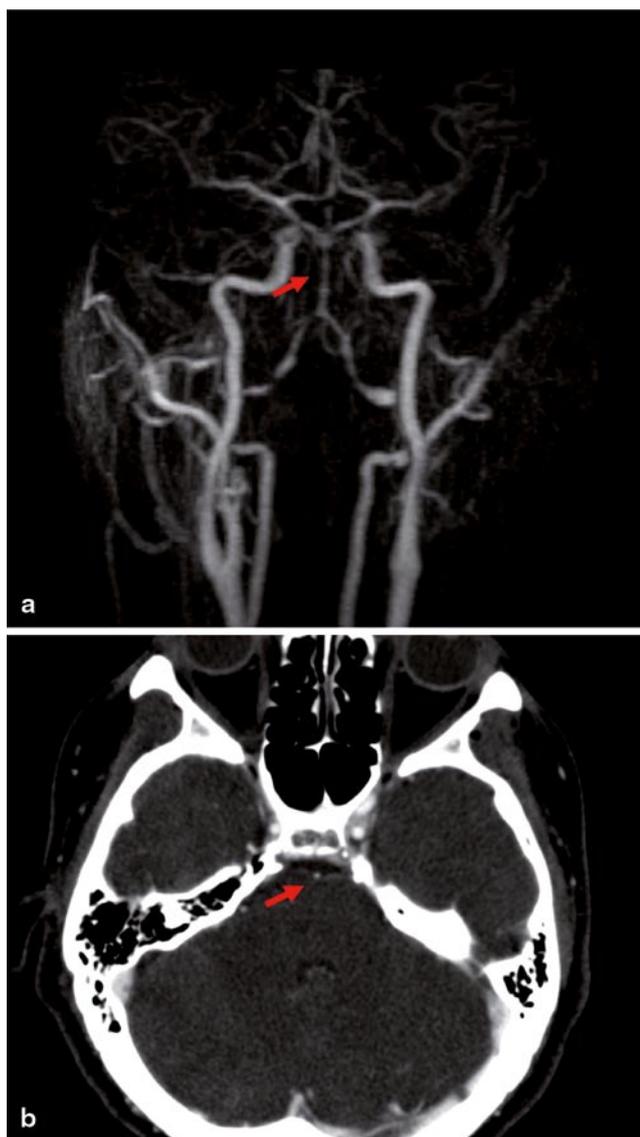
a MRI, time-of-flight (TOF) angiogram showing thin-calibered vertebral arteries bilaterally and a slim and irregularly configured basilar artery as compared with preincidental image (see Fig. 1) as an indirect equivalent to dissection. b CT angiogram prior to reconstruction at midpontine level depicting a very slim basilar artery. A clear difference in vessel caliber is obvious in comparison to Fig. 1, although different imaging modalities have been applied
